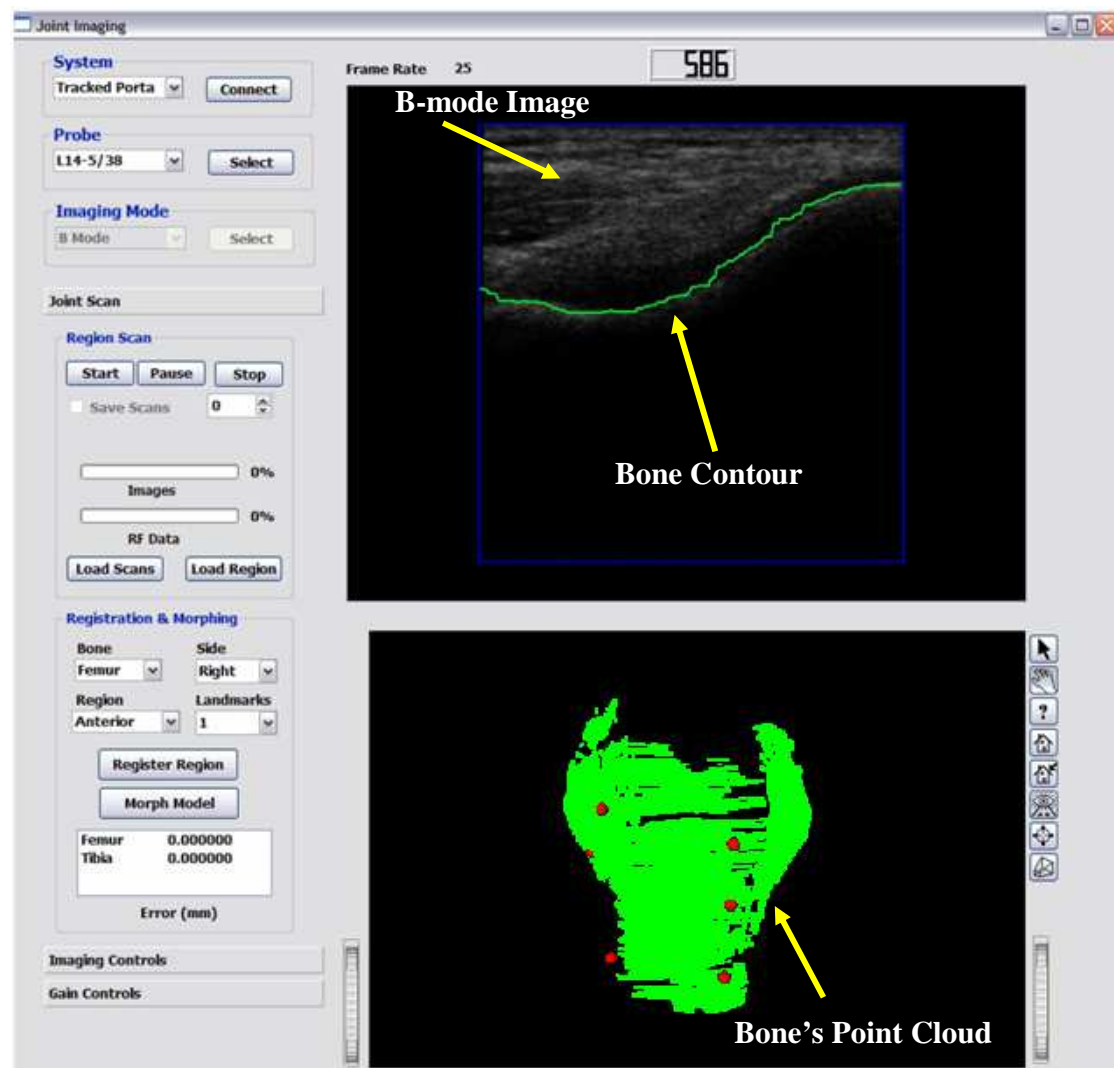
A snapshot of the developed imaging software during scanning of a cadaveric distal femur, showing a B-mode ultrasound image, the bone contour extracted from the ultrasound raw RF data, and the reconstructed point cloud while being reconstructed.
